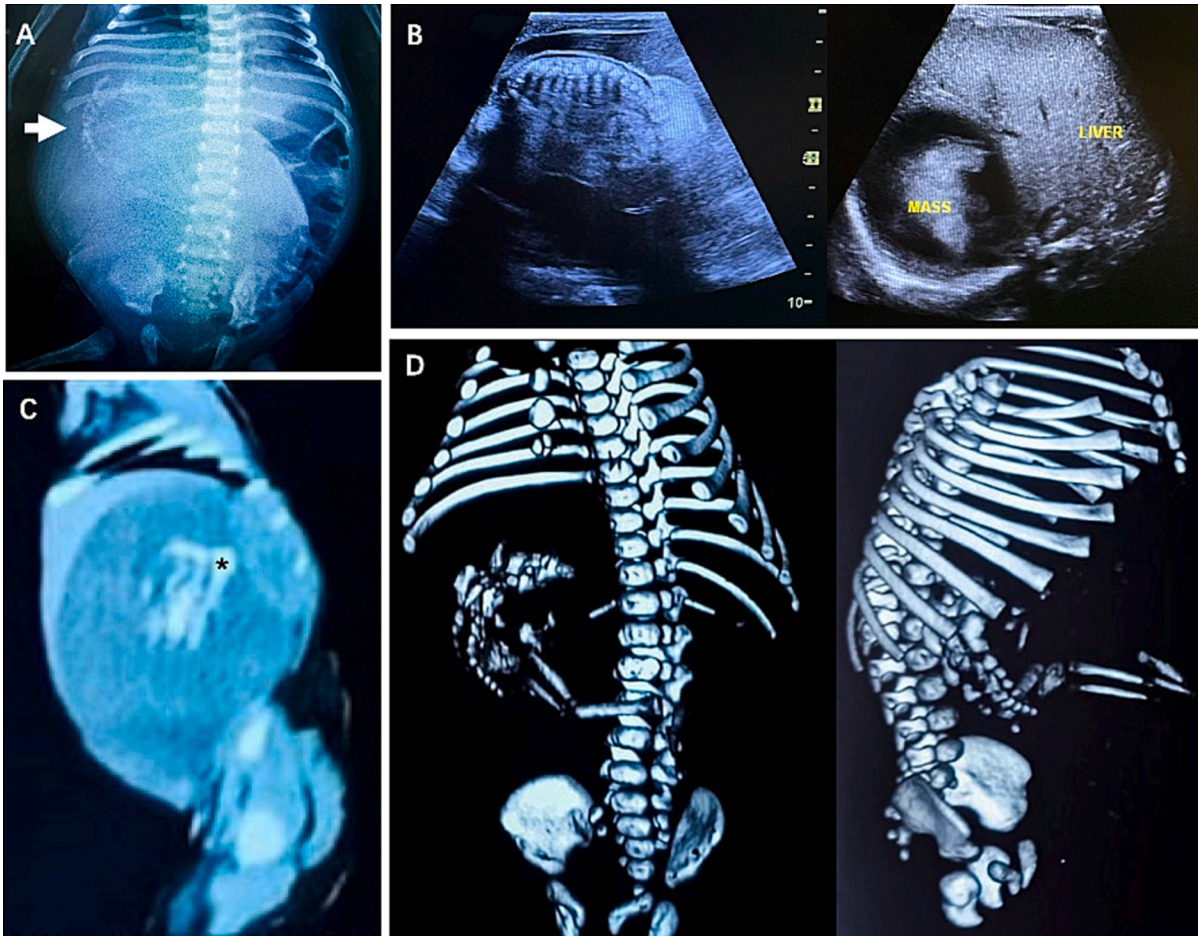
The radiographic, ultrasonographic, and computed tomographic (CT) image of the abdominal region revealed the presence of a complex soft-tissue mass with bony components. (A) Abdominal X-ray showed calcified mass in the right hemiabdomen which is pressing on the intestines. (B) Postnatal abdominal ultrasonography showed a retroperitoneal cystic mass in the right hemiabdomen containing an incomplete fetus, which is pressing on the liver. (C) Sagittal CT scan. In front of the right kidney, there is a soft tissue mass with calcified opacities corresponding to fetal costae. (D) Three-dimensional reconstruction from the abdominal CT scan demonstrated the spatial relationship between autosite's lumbar spine and pelvis with visualized portion of the fetus in fetu's skeleton including vertebral columns, costae, pelvic bones, and bones of the lower extremity.
